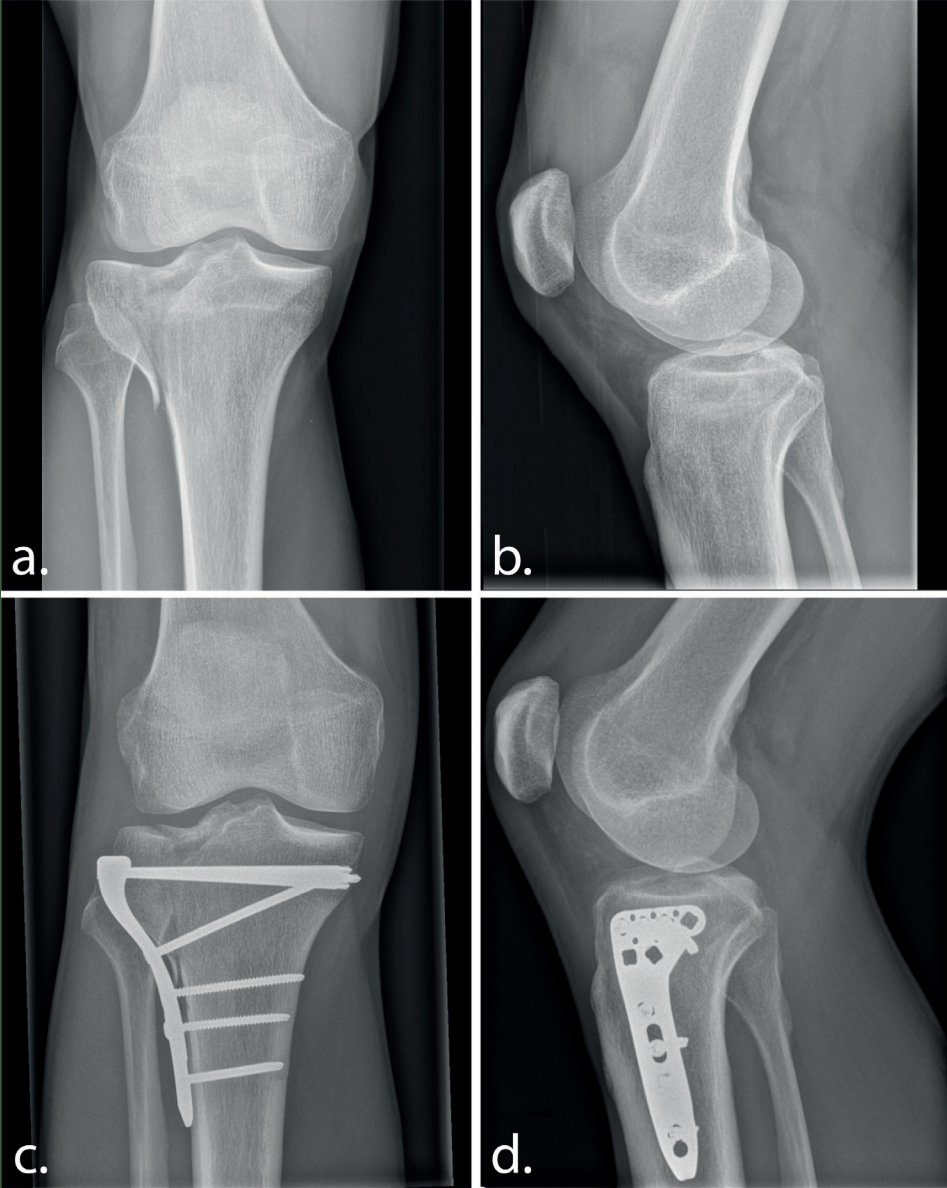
Anteroposterior and lateral radiograph of the initial tibial plateau fracture (a &b) and of the situation 1-year postoperative (c&d).
